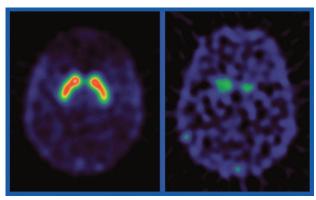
¹²³I-PE21 SPECT has promise as a diagnostic tool in clinically uncertain parkinsonian syndromes. Striking results are seen when this technique is applied in healthy individuals (left) and those who have Parkinson's disease.
